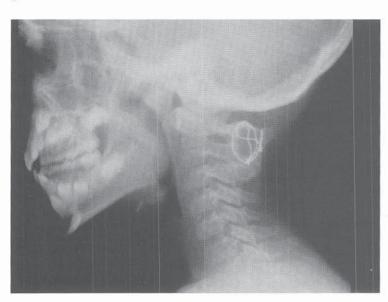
Os odontoideum. A, Radiographic appearance in a child age 4 years 8 months who presented for an AFO prescription for hemiparesis. She had no significant birth history and had walked at a normal age. Neck stiffness and pain were present. B, Tomograph demonstrating os odontoideum. C, Instability on flexion. D, MR image demonstrating lack of cord impingement in extension. E, Gallie fusion in extension was performed. There was no immediate change in the hemiparesis.
